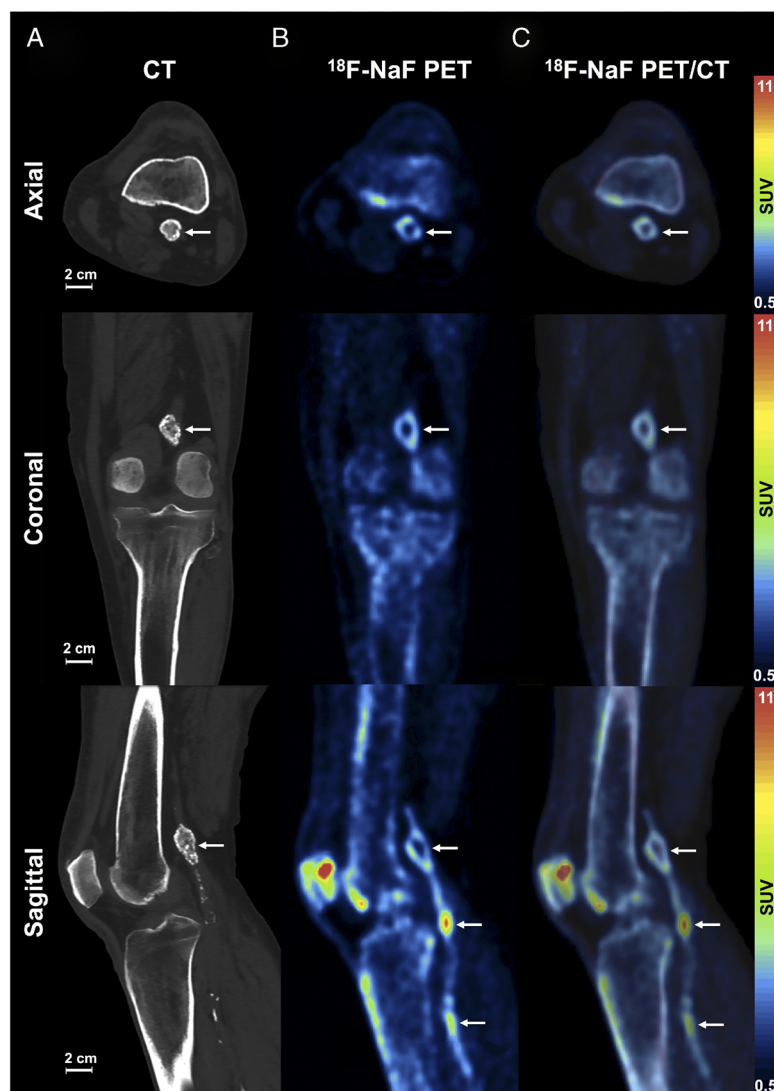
^{18}F -NaF PET/CT imaging of peripheral atherosclerosis. Four years after angiography imaging, the man continued to have mild claudication symptoms and had an ankle-brachial index of 0.62 and a toe-brachial index of 0.47. At this time, he was prospectively enrolled into an ongoing study evaluating the prognostic value of radiotracer-based imaging in PAD patients (<https://clinicaltrials.gov>, NCT03622359). As an additional component of this study, PET/CT imaging was performed 75 minutes after IV injection of ^{18}F -NaF (370 MBq) to assess the status of active microcalcification in lower extremity arteries. CT imaging detected the extensive macrocalcification of the popliteal aneurysm (A, arrows) that colocalized with the elevated retention of ^{18}F -NaF around the calcified aneurysm on PET (B, arrows) and PET/CT images (C, arrows), suggesting ongoing remodeling of the aneurysm. PET/CT also demonstrated increased focal uptake of ^{18}F -NaF in 2 distal vascular sites (B and C, arrows) that did not coincide with prominent macrocalcification on CT images, thereby indicating potential early stages of microcalcification in additional atherosclerotic plaques. ^{18}F -NaF PET/CT imaging has emerged as a tool that offers dual assessment of macrocalcifications (via CT) and the process of active microcalcification associated with atherosclerosis (via ^{18}F -NaF PET),¹ with ^{18}F -NaF uptake being shown to localize to arterial segments that are undergoing active microcalcification.^{2,3} Although ^{18}F -NaF PET/CT imaging investigations have traditionally evaluated coronary artery plaque remodeling,¹ recent work has also begun to assess the utility of PET/CT for evaluating abdominal aortic aneurysms,⁴⁻⁷ carotid arteries,^{8,9} and femoral arteries.^{10,11} This report documents a case of active microcalcification in a lower extremity aneurysm and in below-the-knee arteries using ^{18}F -NaF PET/CT. Further application of PET/CT imaging in PAD patients could provide novel insight into the calcification of peripheral arteries and aneurysms, thereby potentially providing guidance for therapeutic strategies and lifestyle modifying behaviors focused on preventing and/or inhibiting the development of life-limiting and limb-threatening peripheral atherosclerosis.
